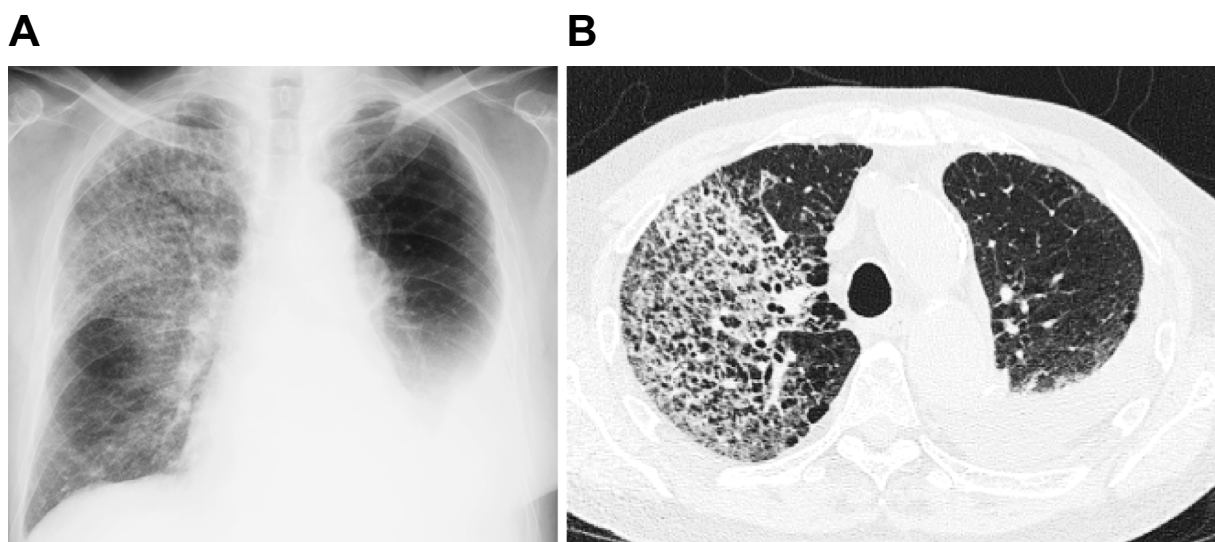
Chest X-ray film (A) and high-resolution computed tomography (B) on admission demonstrated extensive alveolar infiltration in the right lung, and left pleural effusion due to left lower lobectomy.
